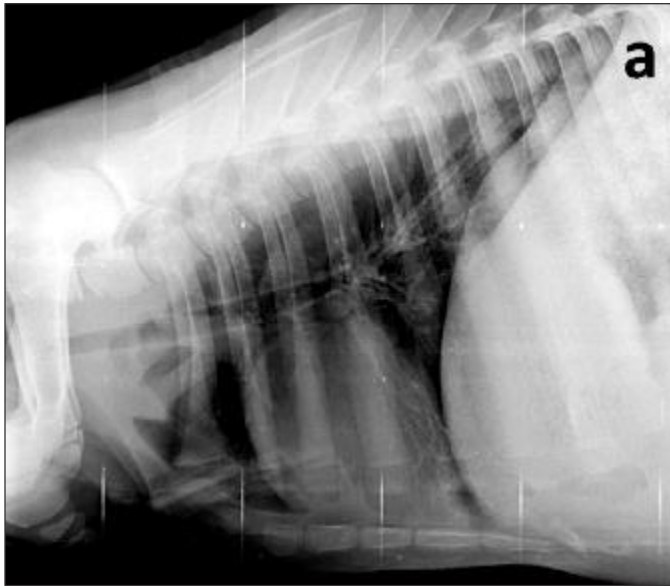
Chest radiograph of the calf suffering from secondary cleft palate showing mild alveolar pattern in caudal and accessory lung lobes (a). The echocardiogram of the same calf in right parasternal longitudinal view showing no apparent congenital abnormality (b).
